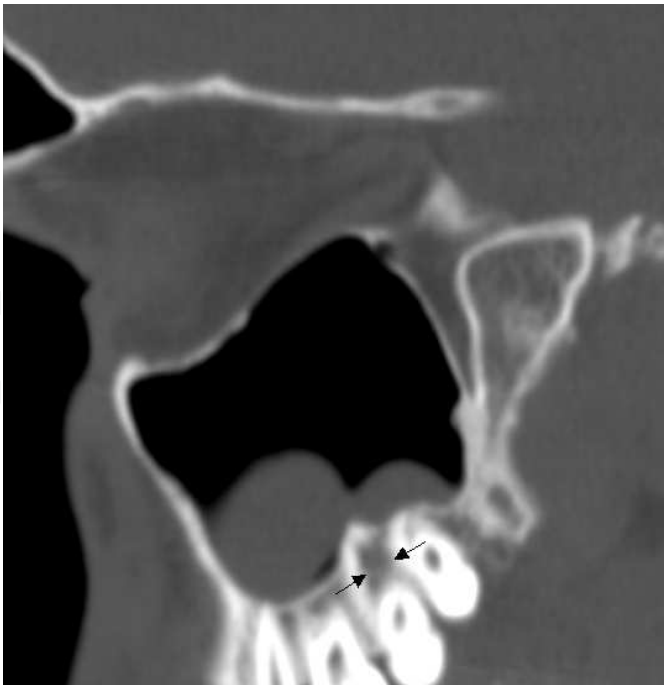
Sagittal CT shows polypoid mucosal thickening in the maxillary sinus due to underlying odontogen infection (arrows).
